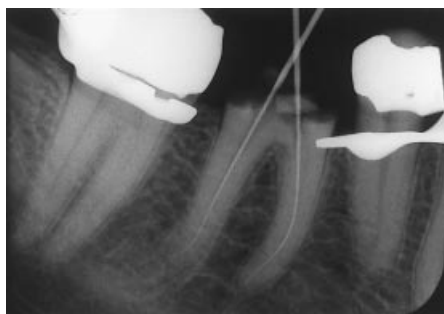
Radiograph showing files in place for length determination and loss of coronal tooth structure.
